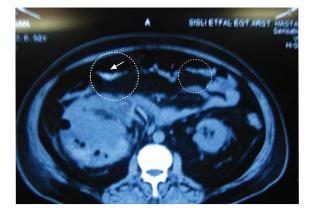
Non-contrast transverse CT scan showing that the right kidney is bigger than normal and images of the air in the upper pole.
